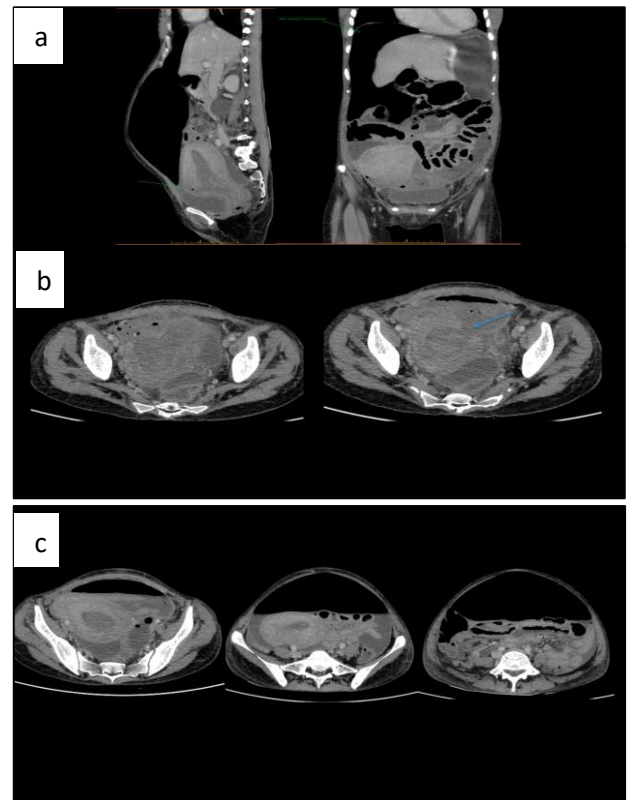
(a) CT abdomen coronal plane showing moderate to gross pneumoperitoneum extending into endometrial cavity through full thickness defect involving anterior myometrium in lower uterine segment suggesting uterine scar dehiscence. (b, c): CT abdomen axial plane showing endometrial collection with air foci and intraperitoneal collection with multiple air foci. There is the continuity of air and fluid between endometrium and peritoneal cavity.
